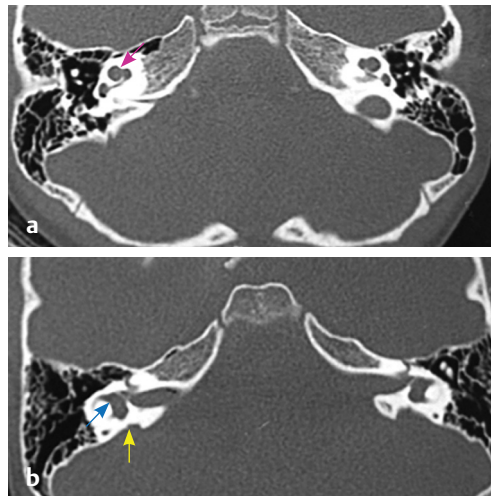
(a, b) HRCT temporal bone, bone window, axial sections show Mondini dysplasia: IP2 - with cystic apical part of cochlea (pink arrow), dilated vestibule (blue arrow), and EVA (yellow arrow).
